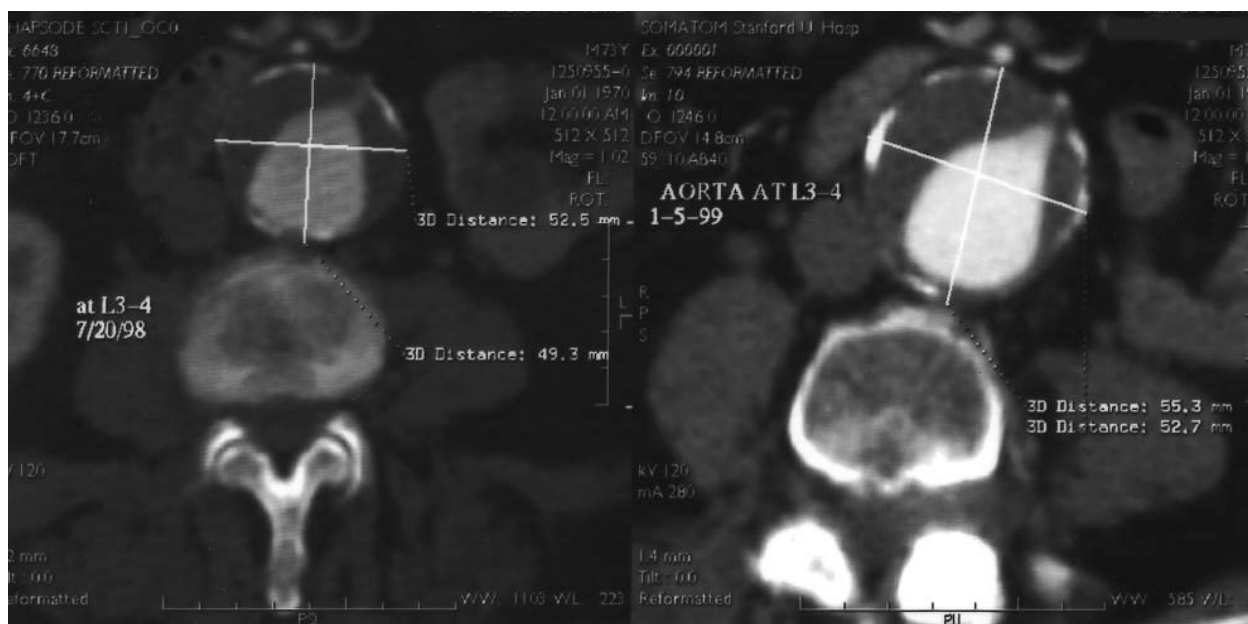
CT scanning assesses the size of the aneurysm, the amount of mural thrombus present, and the relation of other intra-abdominal structures to the aneurysm.
